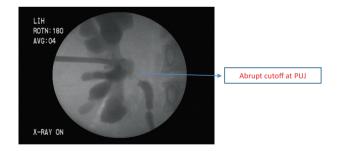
PUJO evaluated by CT-urography and/or antegrade dye study through the pre-placed nephrostomy tube.
